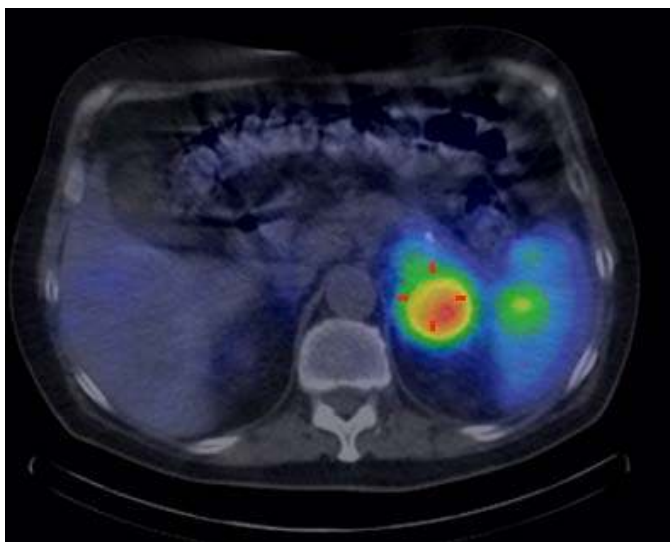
Somatostatin receptor scintigraphy; transversal SPECT/CT fusion image 24h after injection of OctreoScan™ showing a high tracer uptake in the pancreatic NET in the tip of the pancreatic tail.
